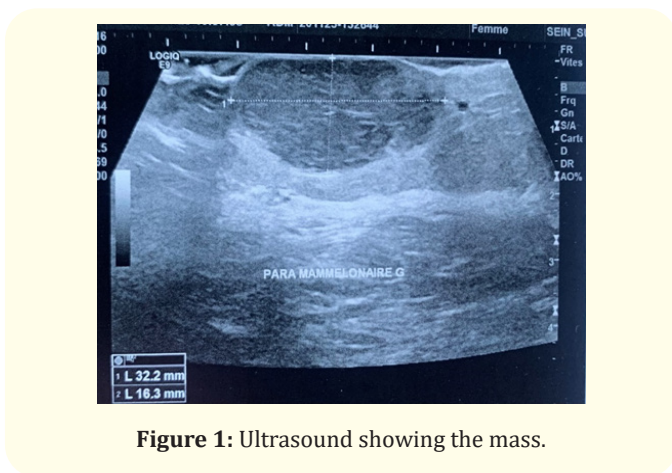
Ultrasound showing the mass.
